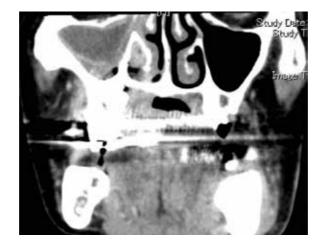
Preoperative CT. Abscess formation is revealed in right maxillary sinus.
